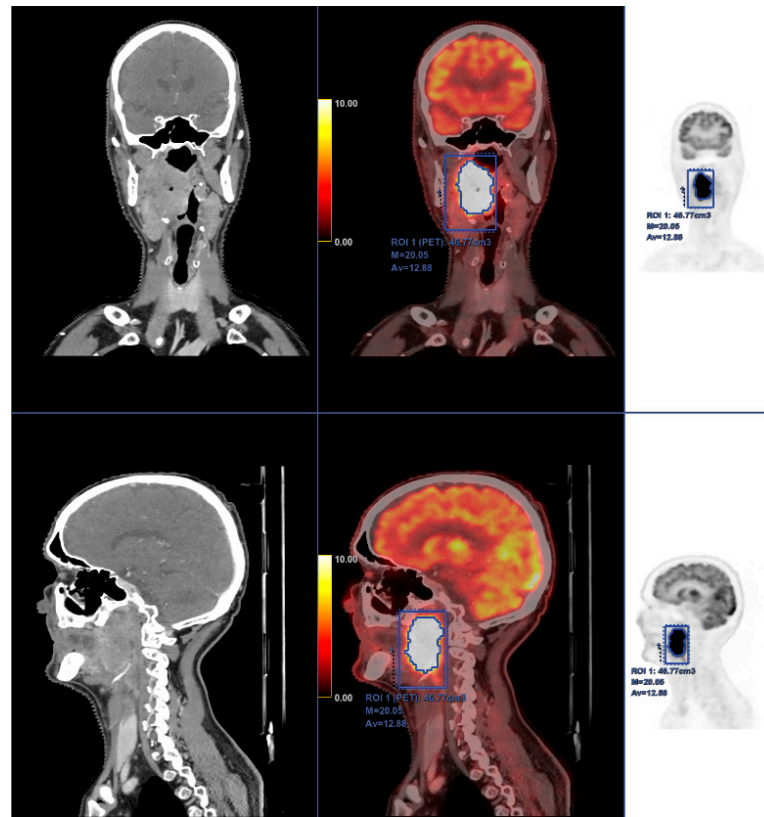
Fifty-eight-year-old male with squamous cell carcinoma of the right tonsil, which is shown to invade adjacent spaces of the oropharynx; especially significant is the invasion of muscular and adipose tissue nearby. Moreover, the tumor causes a reduction of the airway diameter. Intense and homogeneous [^{18}F]FDG uptake is seen in all the malignant tissue as usually identified in these tumors. PET-CT in this case was also used for radiotherapy planning and as a basal study for therapeutic response in subsequent studies.
